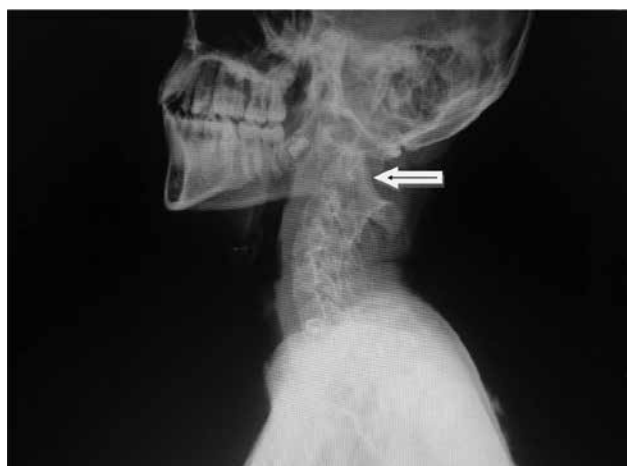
X-ray cervical spine suggestive of atlanto-axial dislocation.
